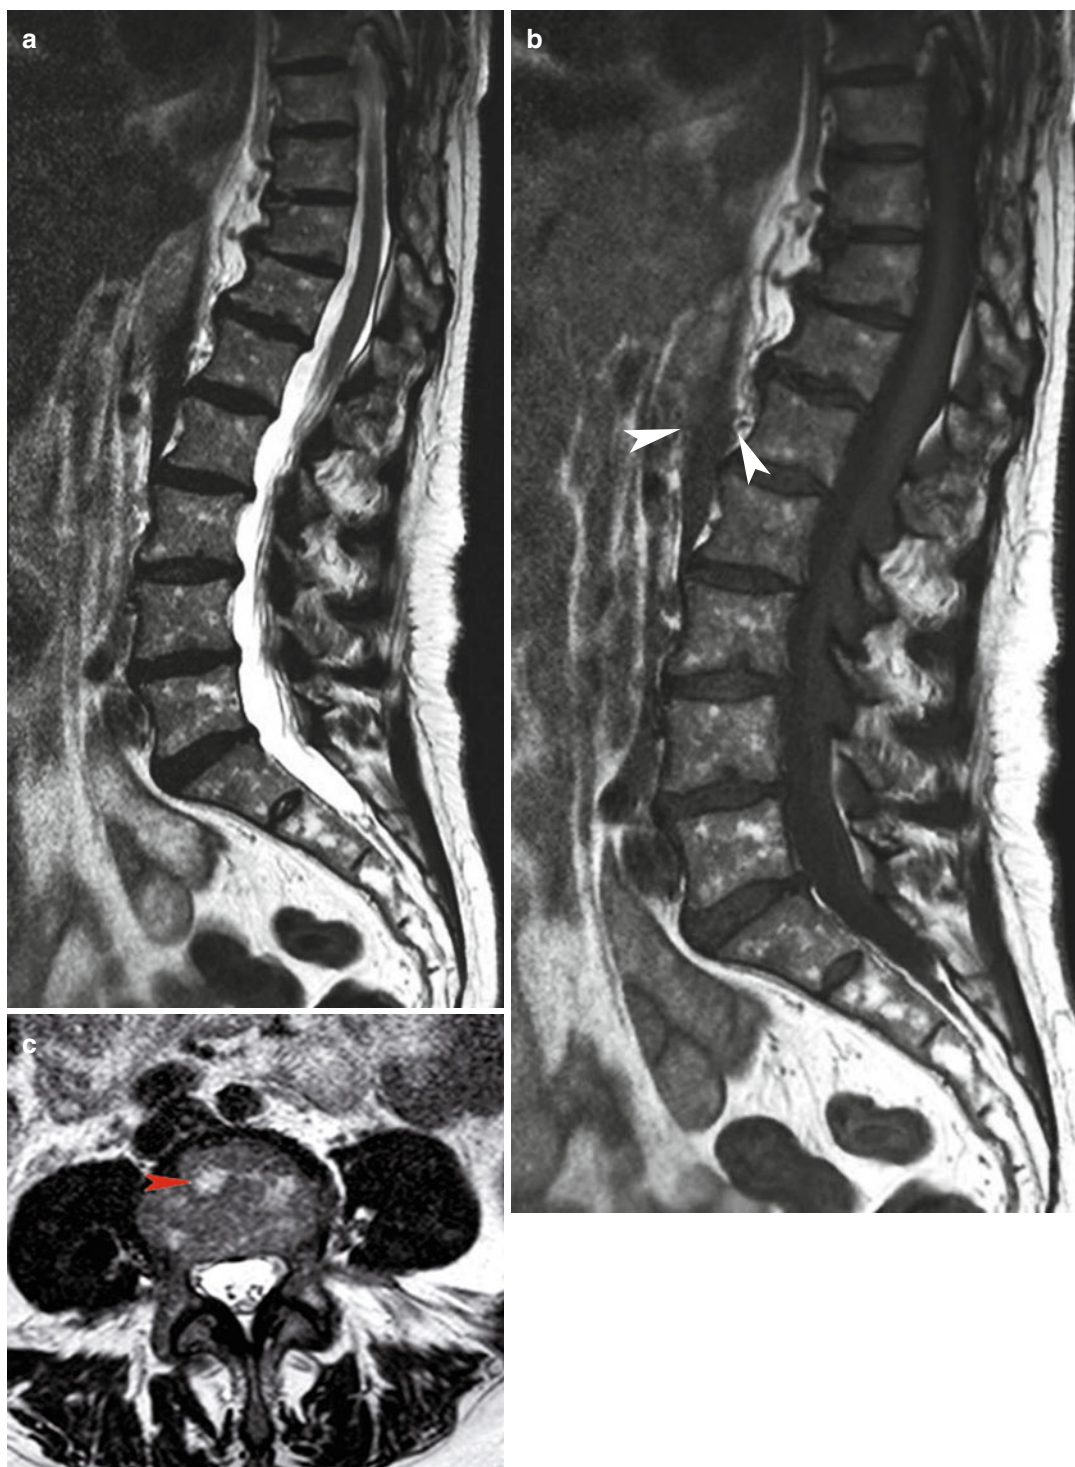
Lumbar sagittal MRI, sagittal TSE T2-weighted (a) and T1-weighted (b), and axial T2-weighted images (c). Adipose degeneration of the haematopoietic bone
